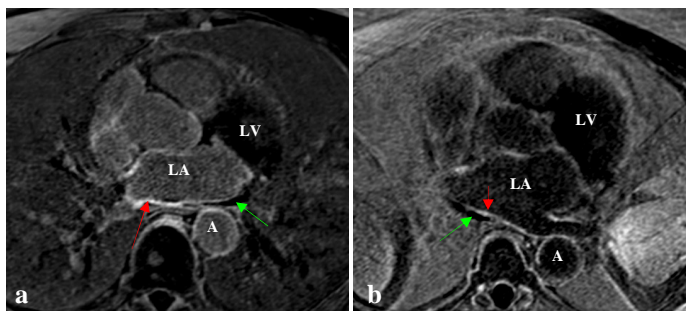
DE-MRI images of left atrium reconstructed using phase-sensitive method. The same images reconstructed by the conventional technique are shown in Fig. 1a and 1b.
